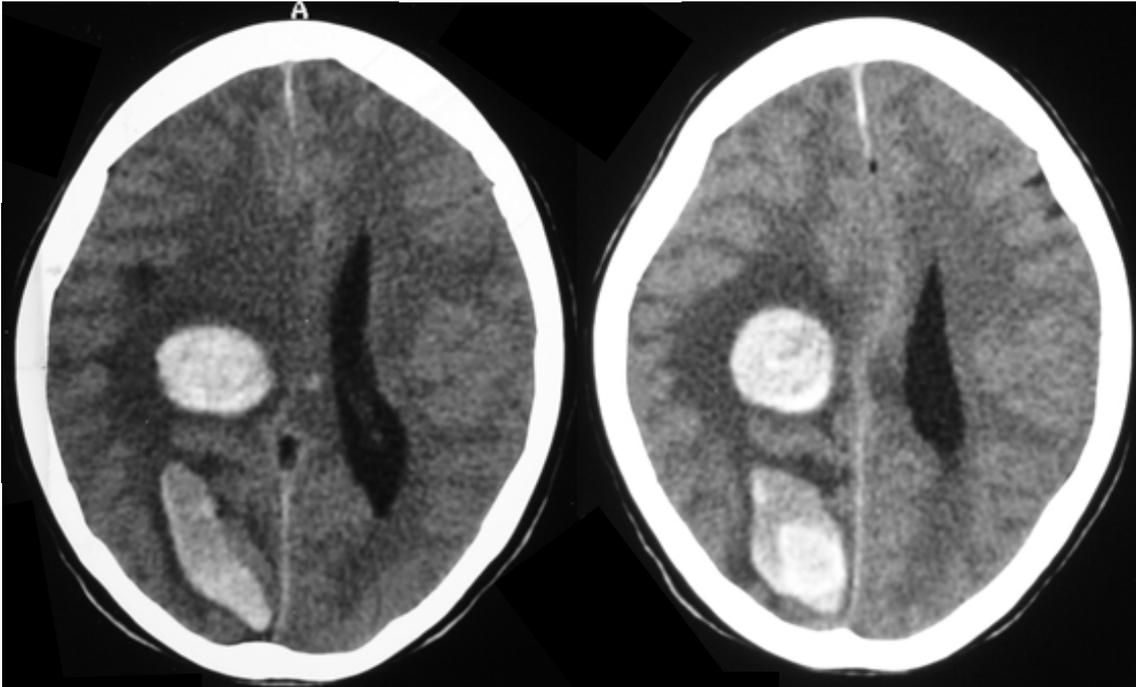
Axial CT images of the brain show a metastasis in the right parieto-occipital region with haemorrhage, perilesional oedema and mass effect.
